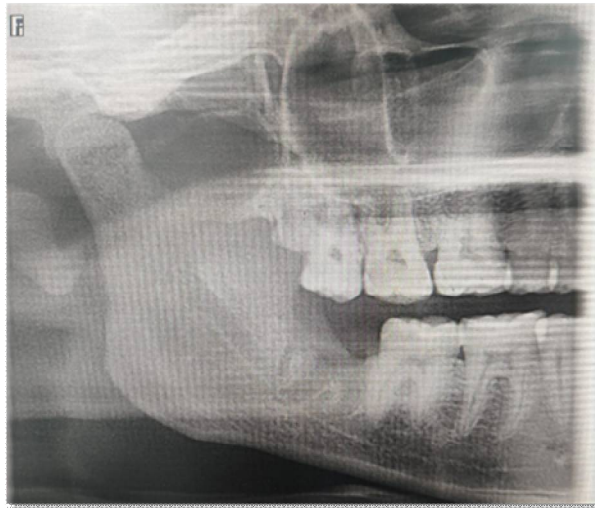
Post operative Intra-Oral Periapical view radiograph showing complete removal of the bur segment.
